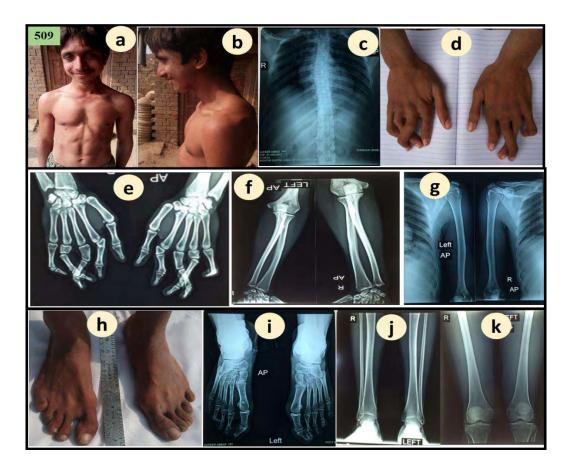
Phenotypic expression and radiographic features of patient 509. Pectus excavatum (a), craniofacial lateral view (b), scoliosis (c), overlapping fingers in hands (d), X-rays of hands and arms (e-g), abnormal feet (h), X-rays of feet (i), narrow space between tibia and fibula (j) and dislocated patella bone (k).
